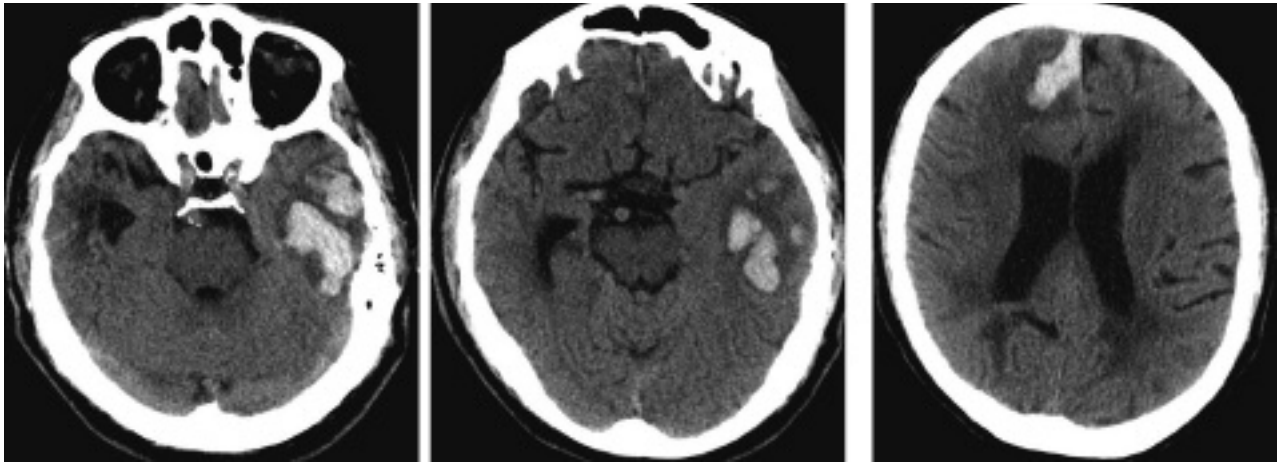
Computed tomogram (CT) images from a man with amyloid angiopathy. At age 76, left temporal hemorrhages (left, middle) were discovered after he presented with confusion. Note sparing of the mesial temporal lobe, including the hippocampus (middle). The left image also shows encephalomalacia associated with remote, right-sided hemorrhage. At age 77, he presented again, with increased confusion, CT imaging (right) revealed right frontal hemorrhage in the cingulate/parasagittal region.
